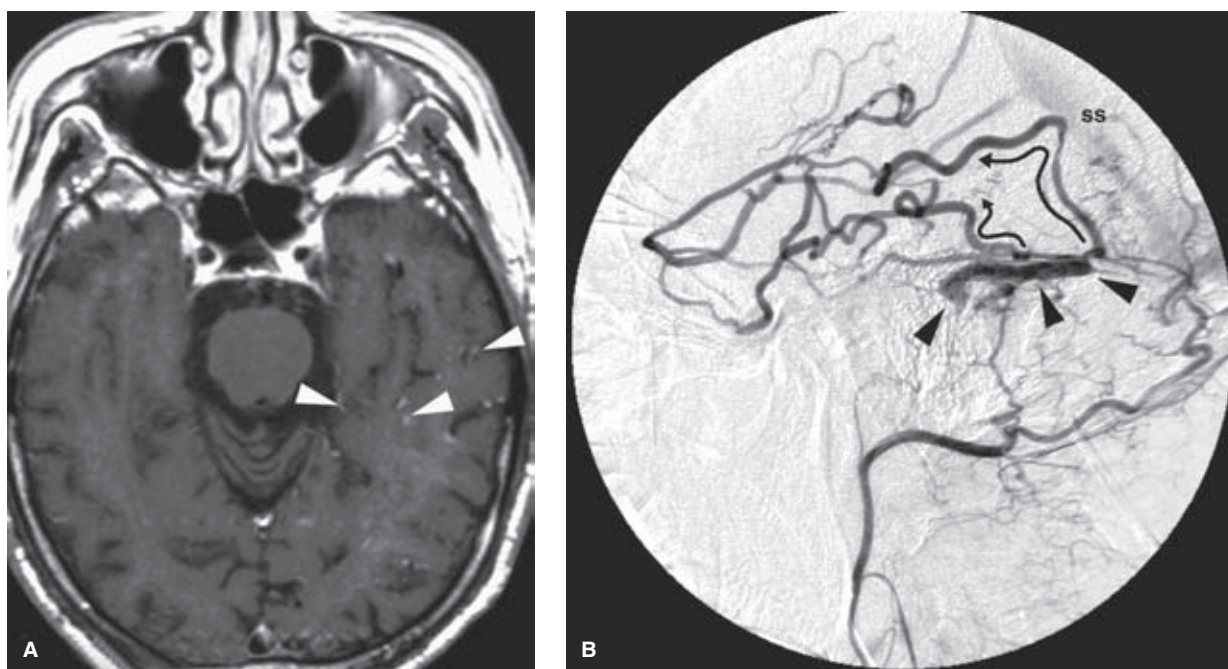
(A–B) Venous hypertension due to a DAVM. An elderly male presented with sudden loss of consciousness and seizure. A CT scan (not shown) demonstrated a small intraparenchymal bleed of the left occipital lobe. An axial image from a T1-weighted contrast-enhanced MRI sequence (A) shows a profusion of enhancing vessel-like structures (*arrowheads*) through the left hemisphere. A DAVM of the left transverse sinus was found by angiography. A lateral view of the left occipital artery injection (B) shows that the involved segment of transverse sinus (*arrowheads*) is isolated from the remainder of the sinus. Therefore, this segment of transverse sinus decompresses via cortical veins to the occipital and temporal lobes (*curved arrows* indicating direction of flow). This causes an extreme elevation of venous pressure throughout the left cerebral hemisphere, which resulted in the patient's condition of venous infarction and hemorrhage (*ss*, straight sinus).
